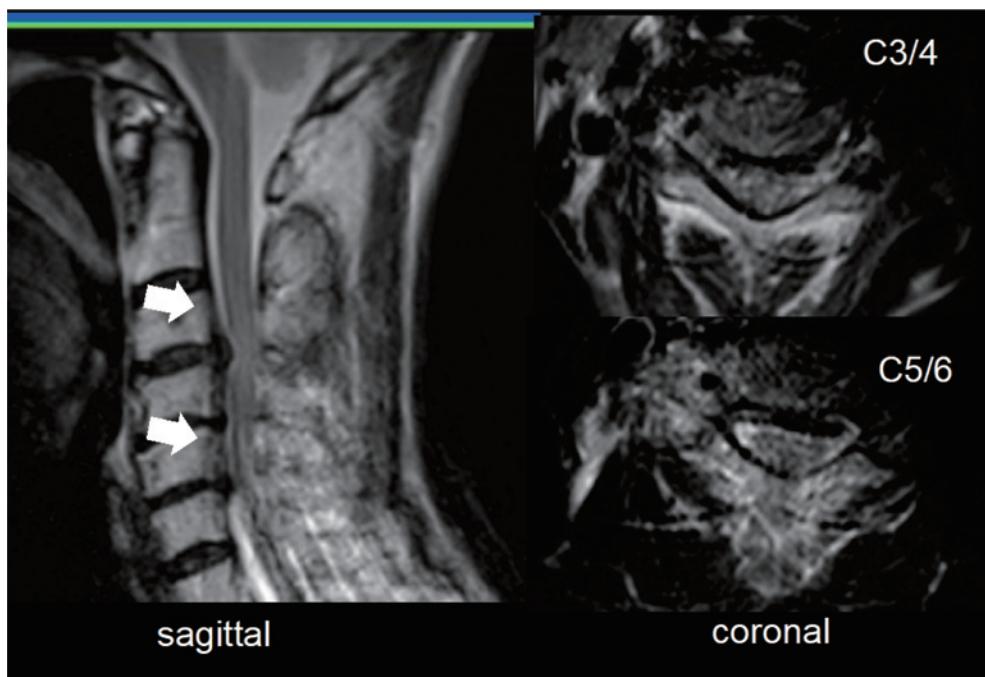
MRI T2-weighted images of the cervical spine
